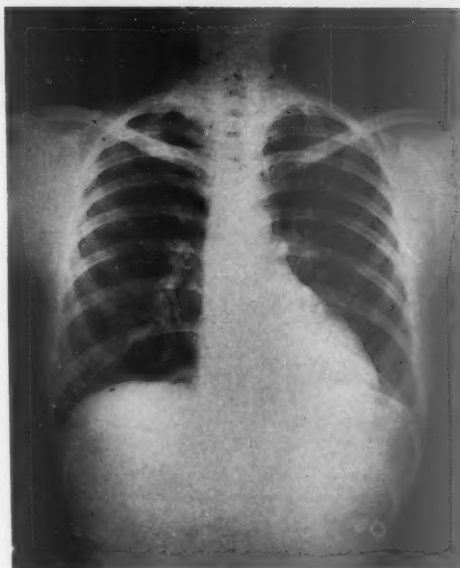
An x-ray of the chest showed a small aortic knob and notching of the ribs.
